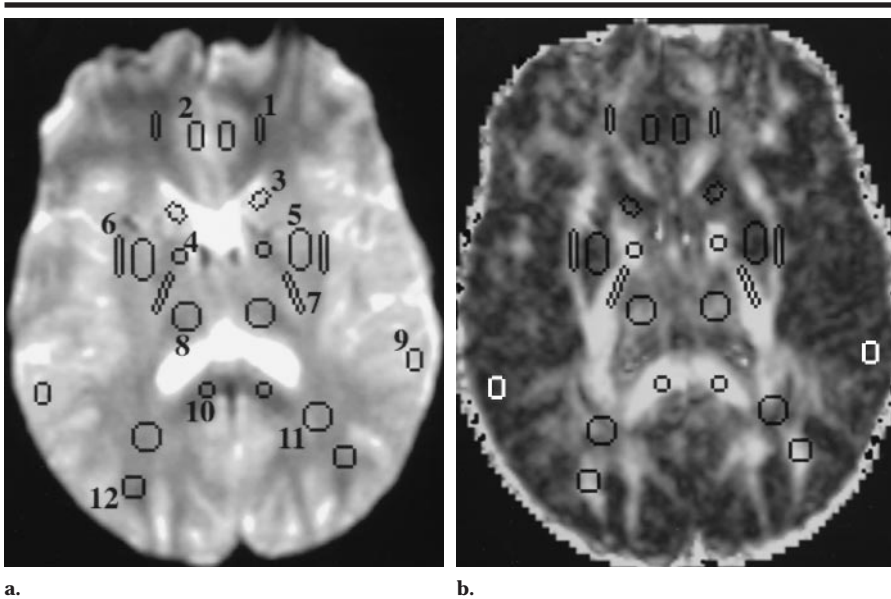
ROIs used in data analysis are superimposed on (a) axial T2-weighted reference MR image (echo time = 106 msec, repetition time > 8,000 msec) (same image as Fig 1, *h*) and (b) axial A_v MR image (same image as Fig 2, *a*). 1 = frontal WM, 2 = frontal GM, 3 = head of the caudate nucleus, 4 = genu of the internal capsule, 5 = putamen, 6 = external capsule, 7 = posterior limb of internal capsule, 8 = thalamus, 9 = occipital-temporal GM, 10 = splenium of the corpus callosum, 11 = occipital WM, and 12 = optic radiations. The location of the ROI for occipital-temporal GM varied across subjects. ROI sizes and shapes were kept constant across hemispheres but varied across subjects.
